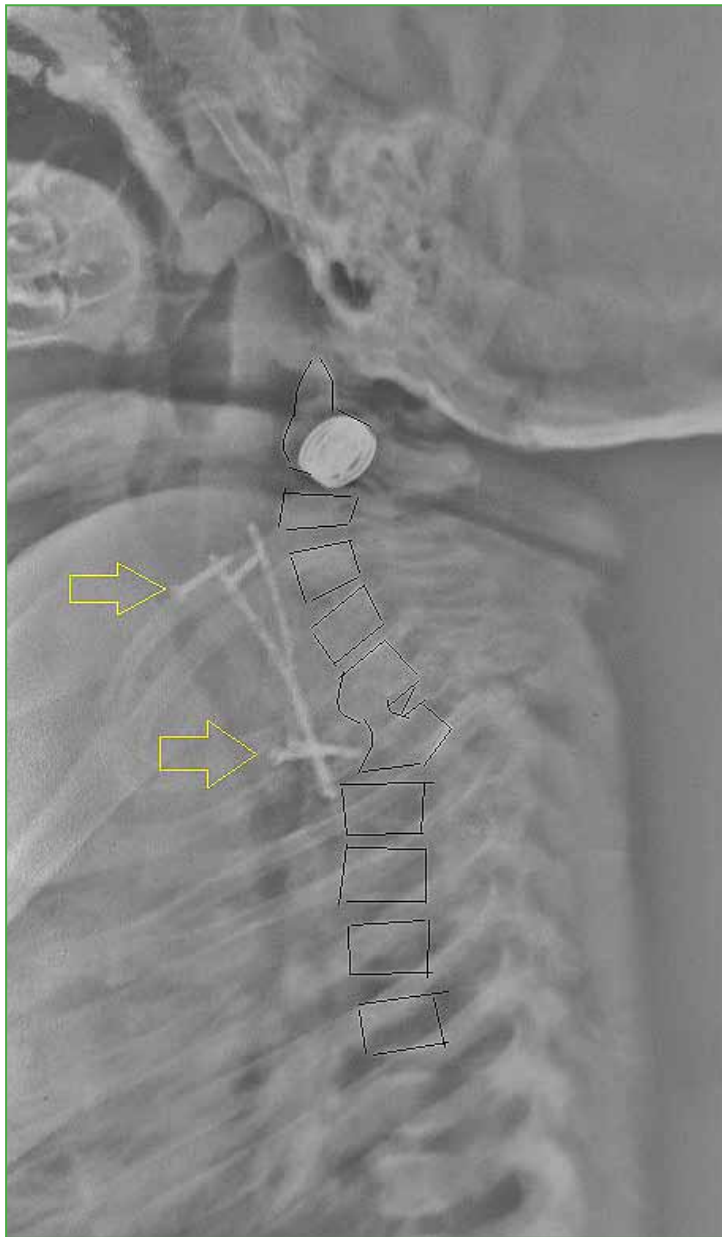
Lateral radiograph of the cervico-thoracic spine 8 months after surgery. Note the partial disassembly of the osteosynthesis (yellow arrows), with slight kyphosis of the focus.
